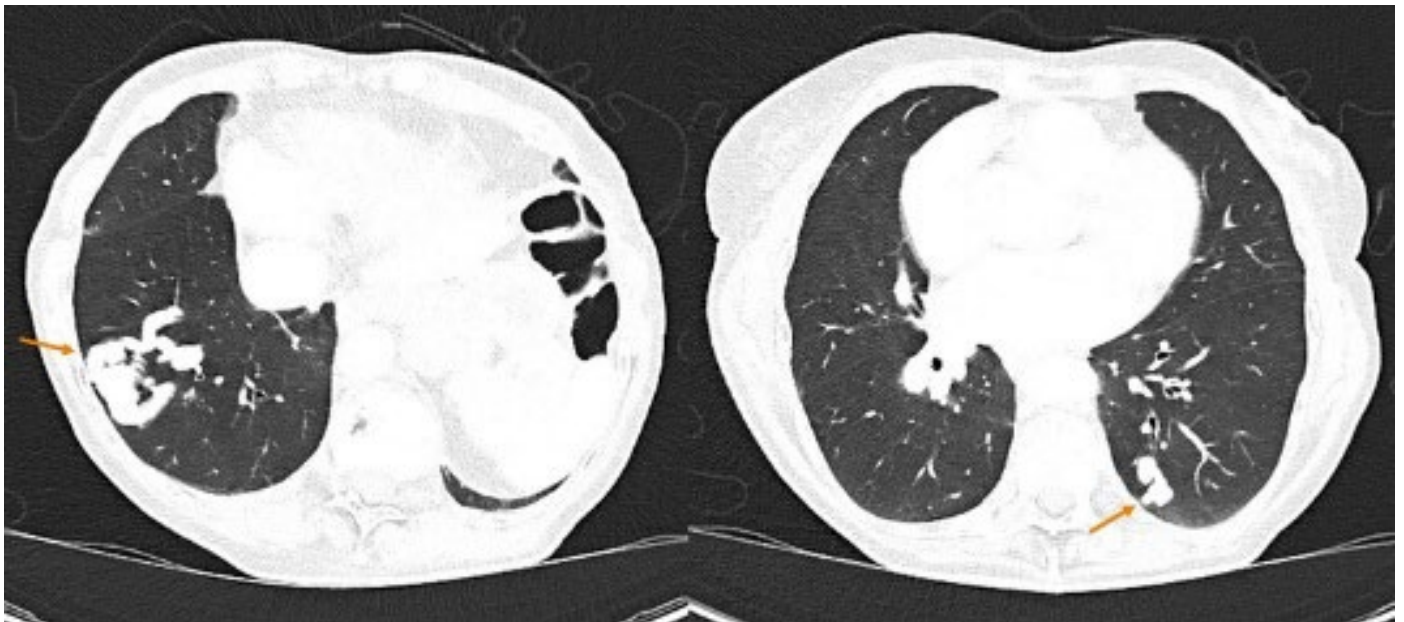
Computed tomography of the chest. Long tubular arteriovenous malformations in both lower lobes (see arrow).
